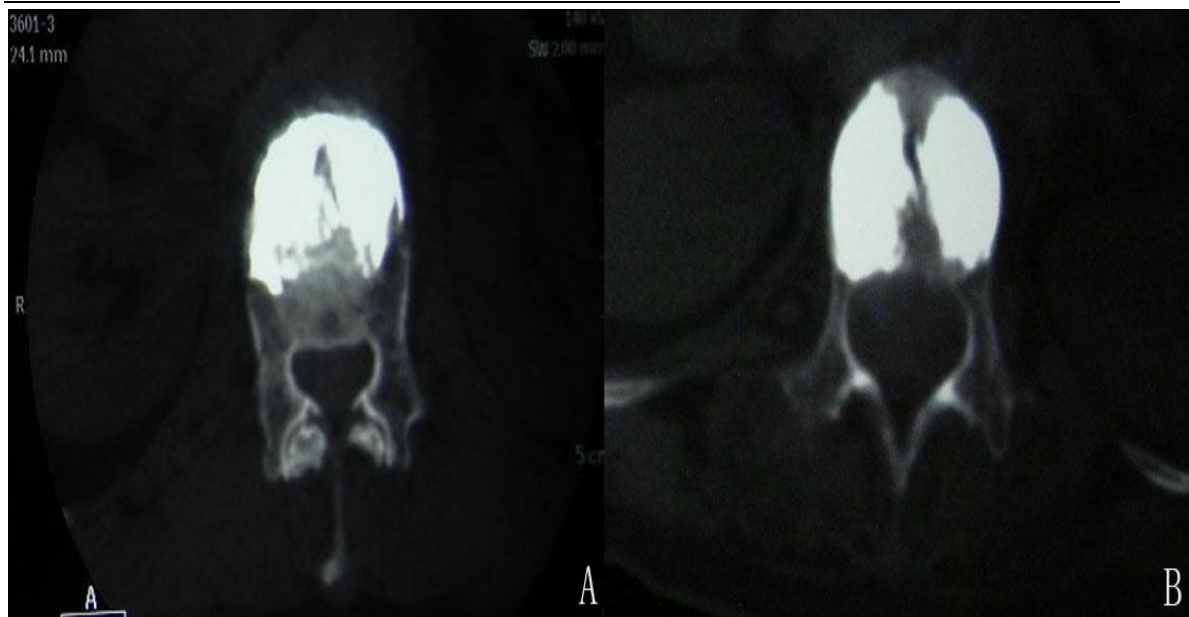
(A) In the unilateral PKP, CT scan revealed that bone cement mainly distributed in the anterior and middle of the vertebral body. (B) In the bilateral PKP, bone cement distributed in the lateral and posterior of the vertebra body. PKP indicates percutaneous kyphoplasty; CT indicates computed tomography.
